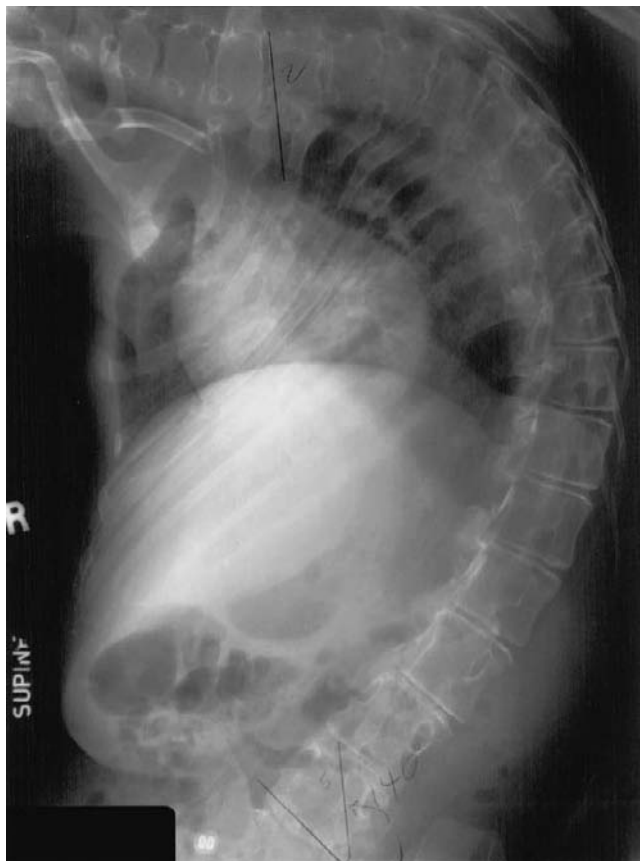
Antero-posterior plain x-ray postpartum showing severity of kyphoscoliosis and distorted intrathoracic contents in a woman with SMA Type II. Reproduced with permission from Yim, R., Kirschner, K., Murphy, E. *et al.* Successful pregnancy in a patient with spinal muscular atrophy and severe kyphoscoliosis. *Am. J. Phys. Med. Rehabil.* 2003; 82: 222–5.
